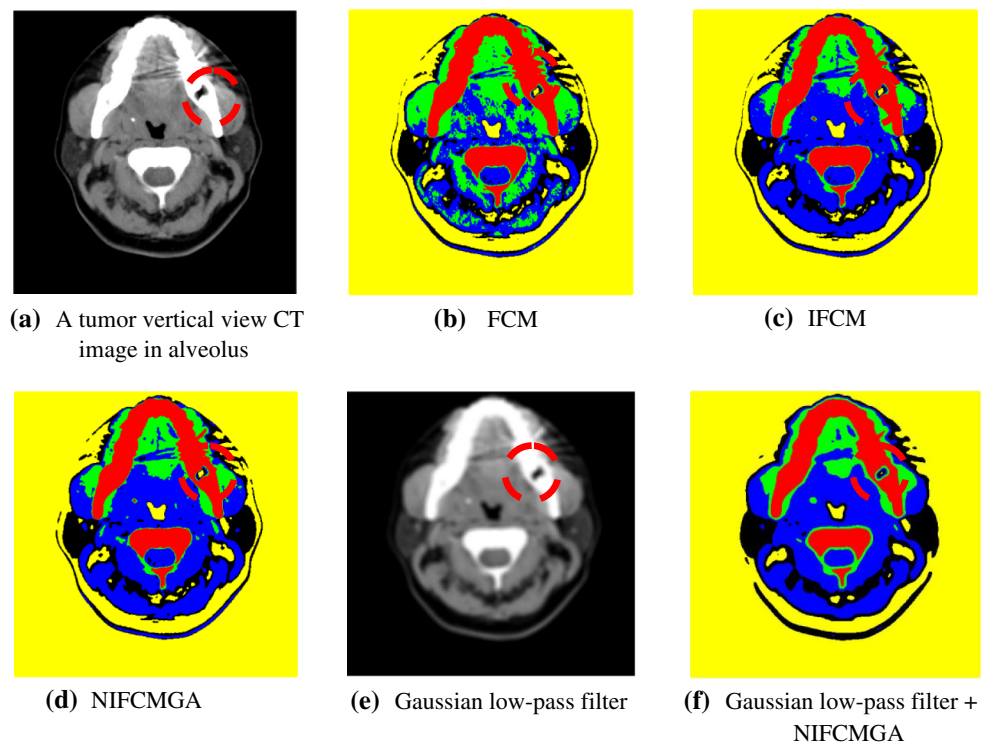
Experimental results of tumor vertical view CT in alveolus with various clustering methods
